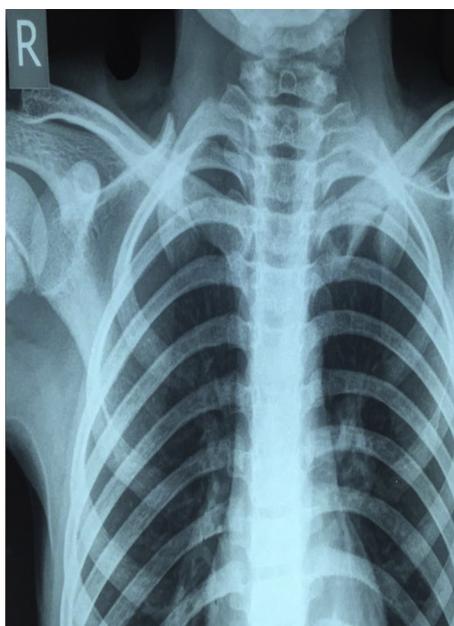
Chest radiograph showing lytic lesion in medial end of clavicle.
